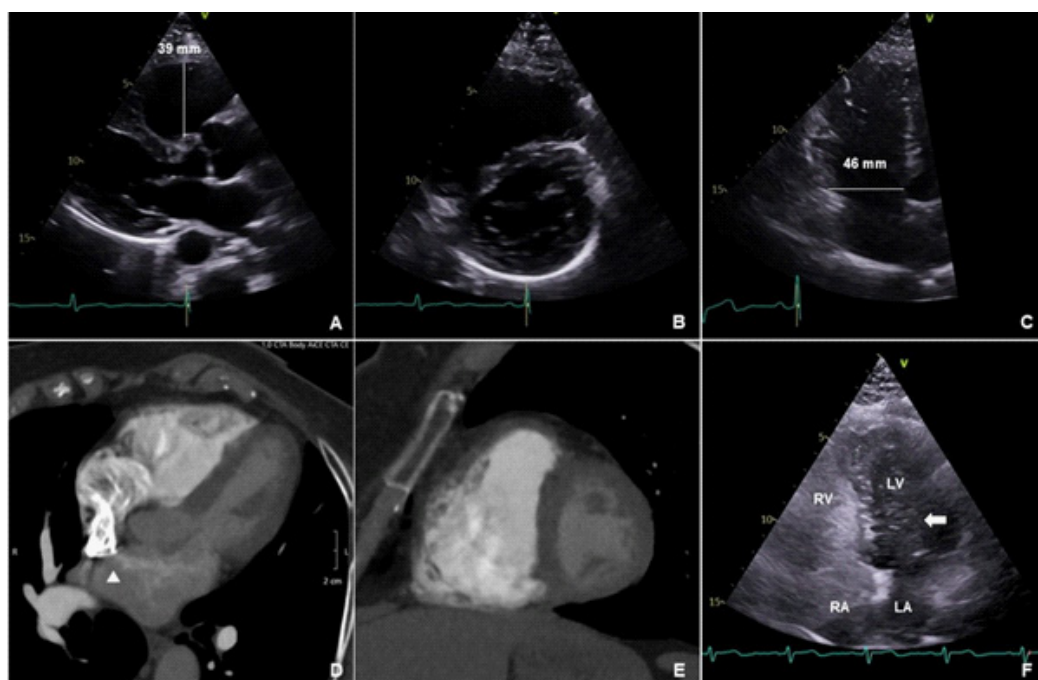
(A-C) Transthoracic echocardiogram images on parasternal long axis, parasternal short axis at the level of the mitral valve, and apical RV focused view showing a dilated RV. (D,E) Cardiac computed pulmonary angiogram showing a dilated RV and possible interatrial communication (arrowhead). (F) Bubble echocardiogram showing a large number of bubbles crossing through the interatrial septum into the left cardiac chambers (arrow). LA: Left Atrium; LV: Left Ventricle; RA: Right Atrium; RV: Right Ventricle.
